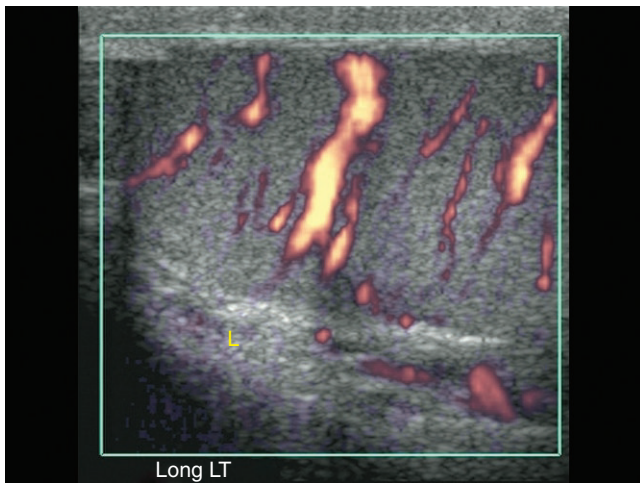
Color Doppler ultrasound of the left (L) testis.
